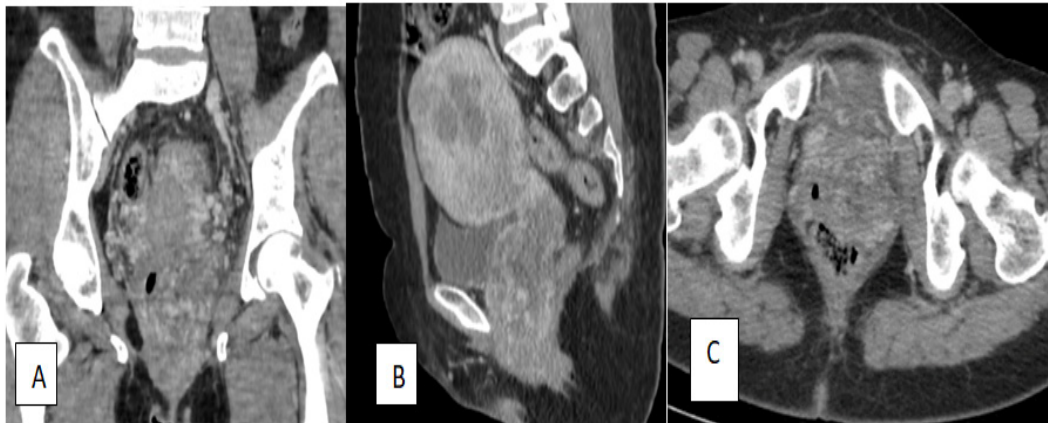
CT scan showing the enlarged uterus measuring 1160 × 95 × 120 mm (HxAPx1), with a poorly defined endocavitary lesion of irregular, circumferential contours occupying the entire uterine cavity.
